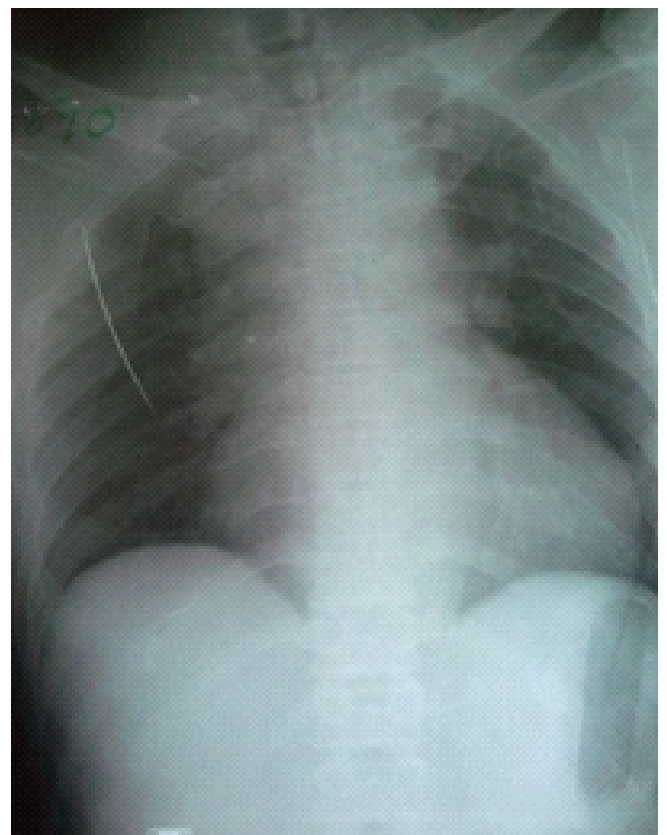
Chest X-ray showing a globular heart shadow and widened mediastinum
